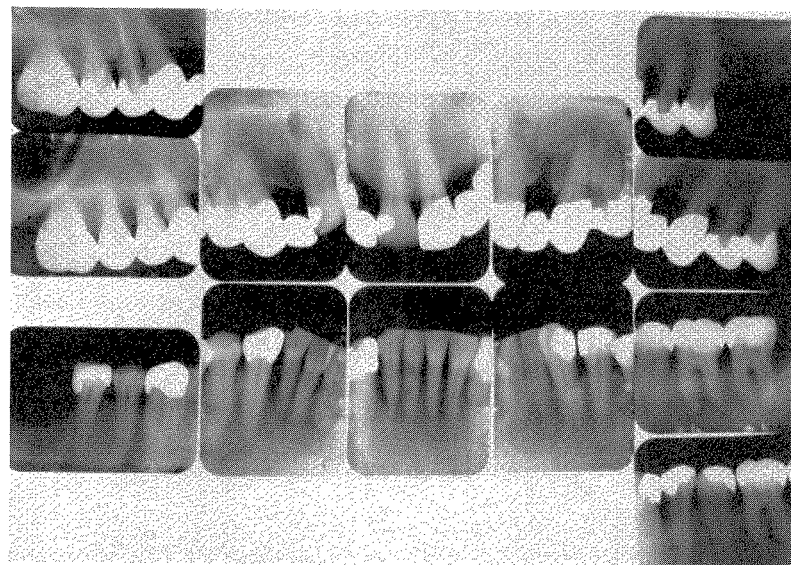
The roentgenograms taken after the rehabilitation was completed are shown here. The lower castings were related to each other by interlocking lugs and lug seats. The lower removable partial denture was constructed in a manner similar to that shown in Figs. 339 and 340.
